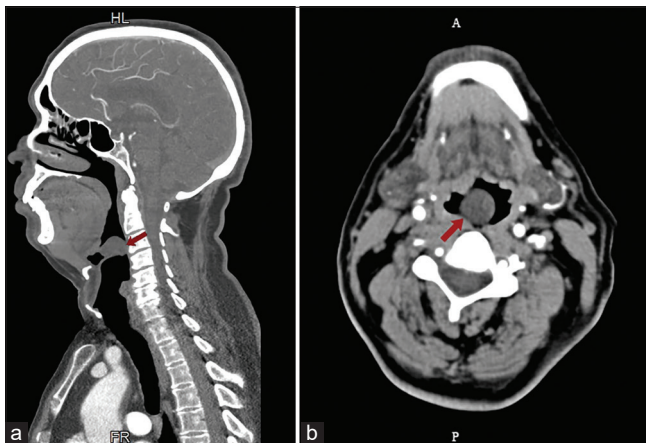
(a) Arrow showing cystic lesion in the vallecula on axial and (b) Sagittal images on computed tomography of head and neck.
